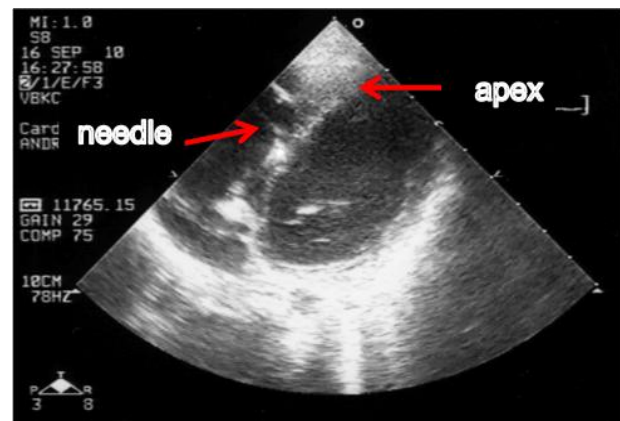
Echocardiographical visualization of transcutaneous intramyocardial injection of stem cells.
